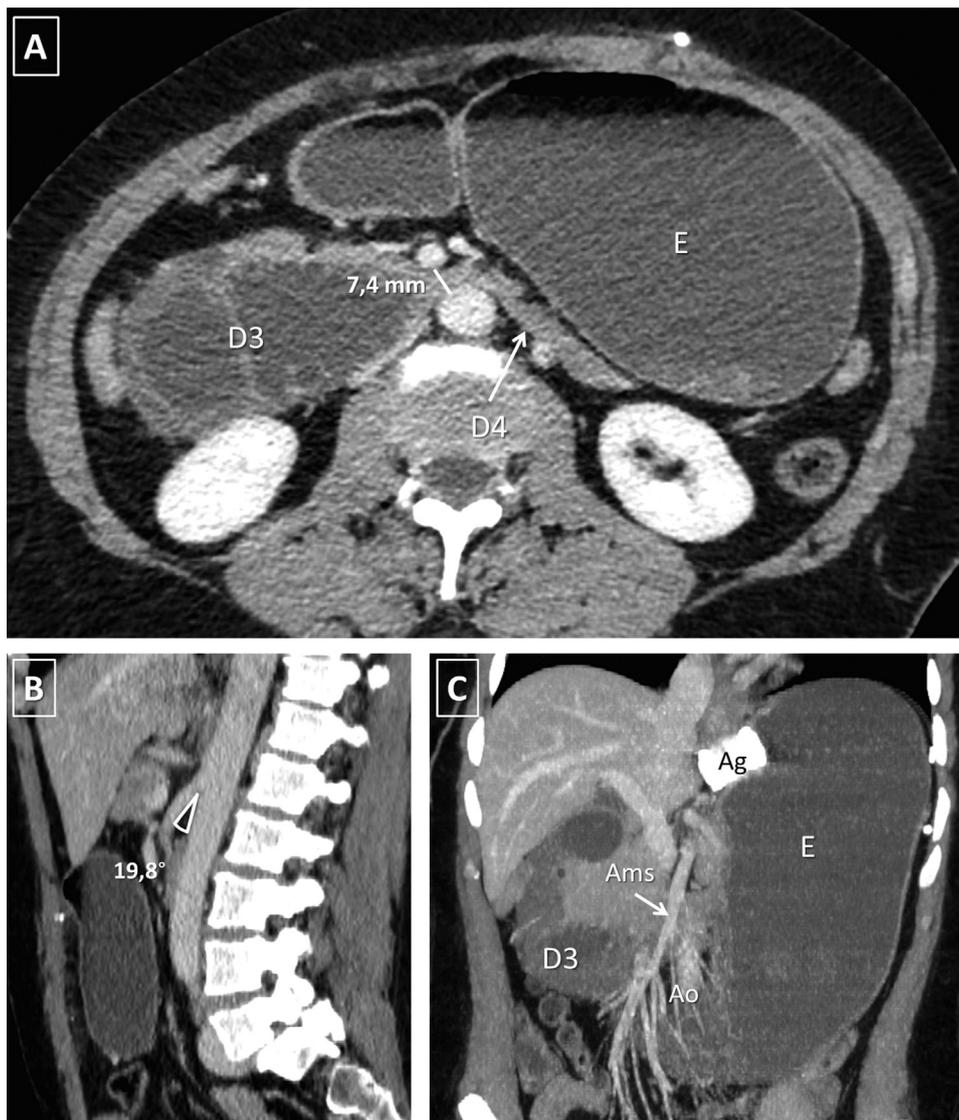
Initial abdominal CT scan. A. Axial cut showing distention of the stomach (E) and the third portion of the duodenum (D3) upstream of compression by the pincer effect of the aorta and the SMA defined as a $< 8\text{ mm}$ distance between the two vessels. The fourth portion of the duodenum (D4) appears flat. B. Sagittal cut showing an aorta-SMA angle of $< 22^\circ$, which defines the SMAS. C. CT reconstruction showing distention of the stomach (E) and D3 between the gastric band (Ag) and the pincers of the aorta (ao) and SMA (ams).
